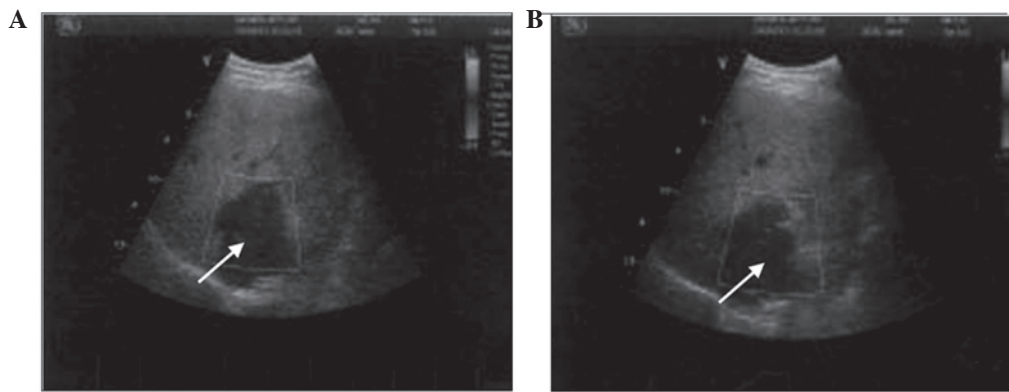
Ultrasound findings of primary liver leiomyosarcoma. (A) Two dimensional scanning showing a large heterogeneous hypoechoic mass (white arrow) in the caudate lobe of the liver. (B) Doppler flow imaging showing no blood flow signal.
